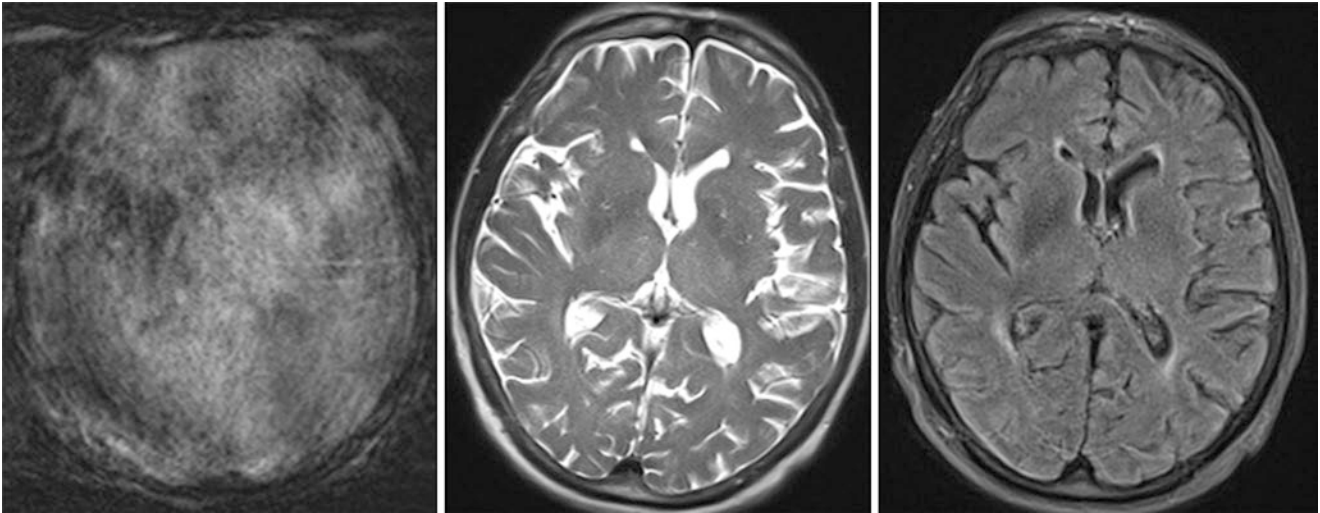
Motion-related artifact. A 67 year old with a severely degraded image on 2-mm-thick SWI (*left*) caused by a severe degree of motion-related artifact. This is mitigated to some degree on ultrafast HASTE-T2WI (*middle*) and on motion-corrected (BLADE) FLAIR (*right*) images at 3T. The trade-off is that these latter two sequences have a lower signal-to-noise ratio
